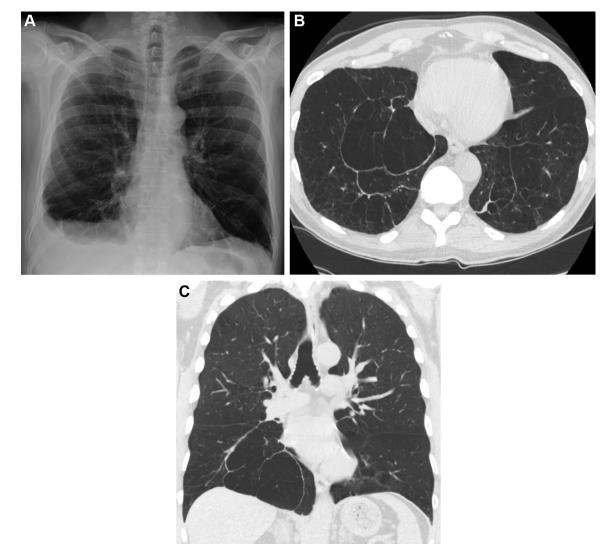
A, Posterior-anterior chest radiograph in a 56-y-old man with ZZ genotype alpha-1-antitrypsin deficiency on augmentation therapy with alpha-1 proteinase inhibitor showing lower lobe predominant hyperexpanded and hyperlucent lungs. B, Axial and coronal (C) CT images on lung windows in the same patient showing severe panacinar emphysema in the lower lobes and centrilobular emphysema in the upper lobes.
